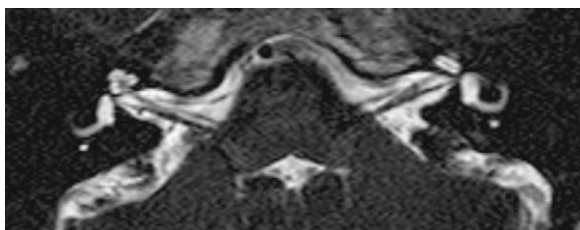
Three-dimensional, T2-weighted, turbo spin-echo, driven equilibrium (TSE DRIVE) transverse image in a patient with continuous left-sided tinnitus. The presence of bilateral deep intrameatal vascular loops (seen to arise from the anterior inferior cerebellar arteries) are most likely incidental.
